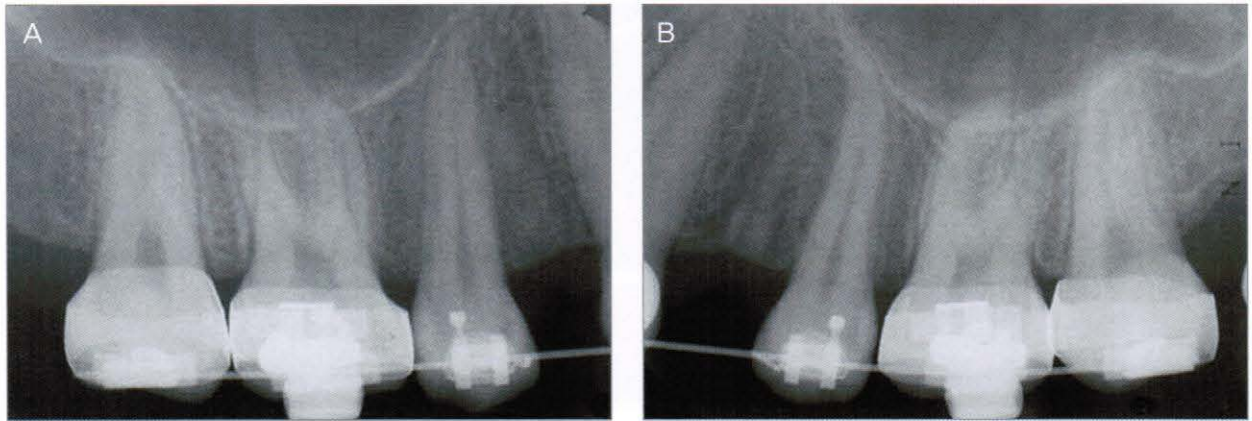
Periapical radiograph taken after leveling up to 016×022' NiTi (2002,11.5)
